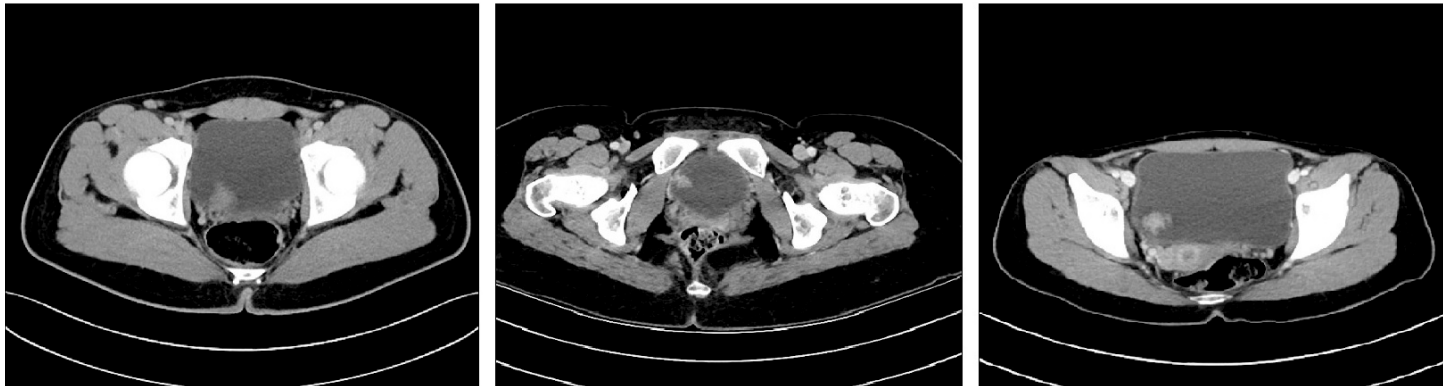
Patients preoperative computed tomography images
